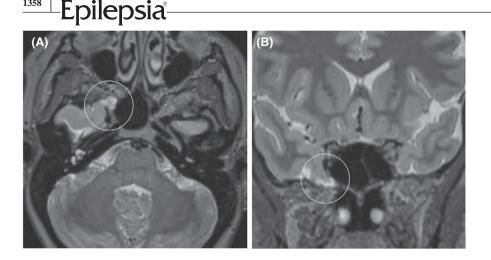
T2 magnetic resonance imaging (MRI) sequences of a patient with left temporal lobe epilepsy (TLE) contralateral to the temporal encephalocele (TE). (A) Axial T2-weighted MRI sequence of a 35-year-old female patient with left TLE and a right TE, contralateral to the epileptogenic zone. (B) T2 coronal MRI of the same patient
